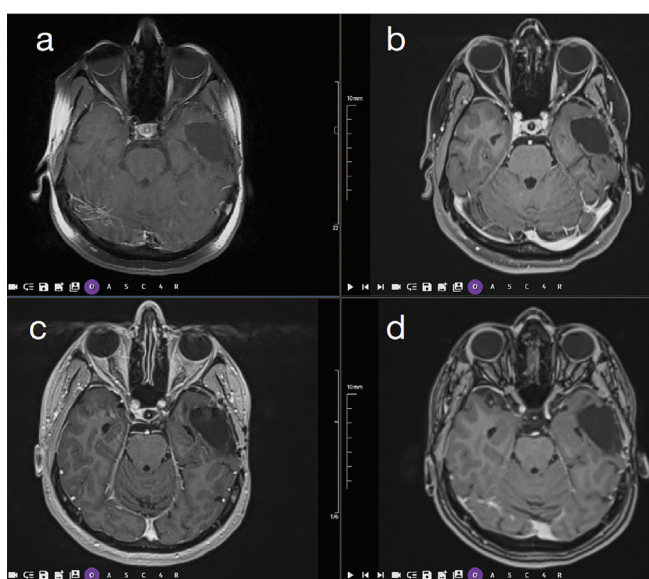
Follow-up magnetic resonance imaging (MRI). Post-contrast fat-suppressed T1-weighted MRI axial images obtained during follow-up show no evidence of residual or recurrent disease in the top row (a, 2018; b, 2020) or the bottom row (c, 2022; d, 2026)
